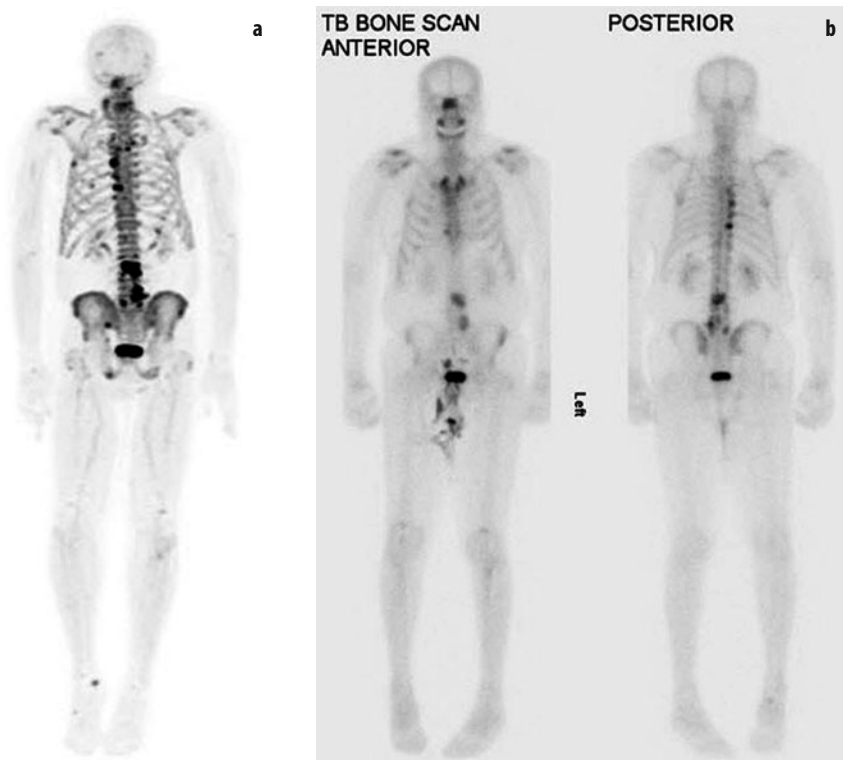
a, b. a Three-dimensional maximum intensity projection (MIP) from [^{18}F]-sodium fluoride (NaF) positron emission tomography (PET) demonstrates an increased number and conspicuity of multiple bone lesions compared with anterior and posterior planar views from b technetium-99m ($^{99\text{m}}\text{Tc}$)-methylene diphosphonate bone scintigraphy in a patient with metastatic prostate cancer
